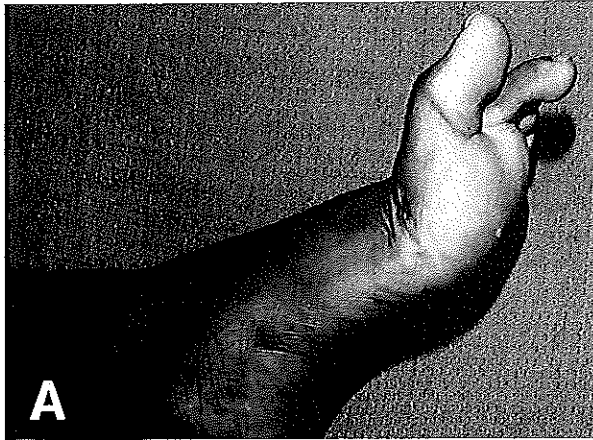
Jahss type IIB dislocation of first MP joint. A, Clinical photograph. B, Prereduction radiograph. C, Postreduction lateral radiograph. D, Postreduction preoperative AP radiograph prior to excision demonstrating wide separation of medial sesamoid fracture fragments.
